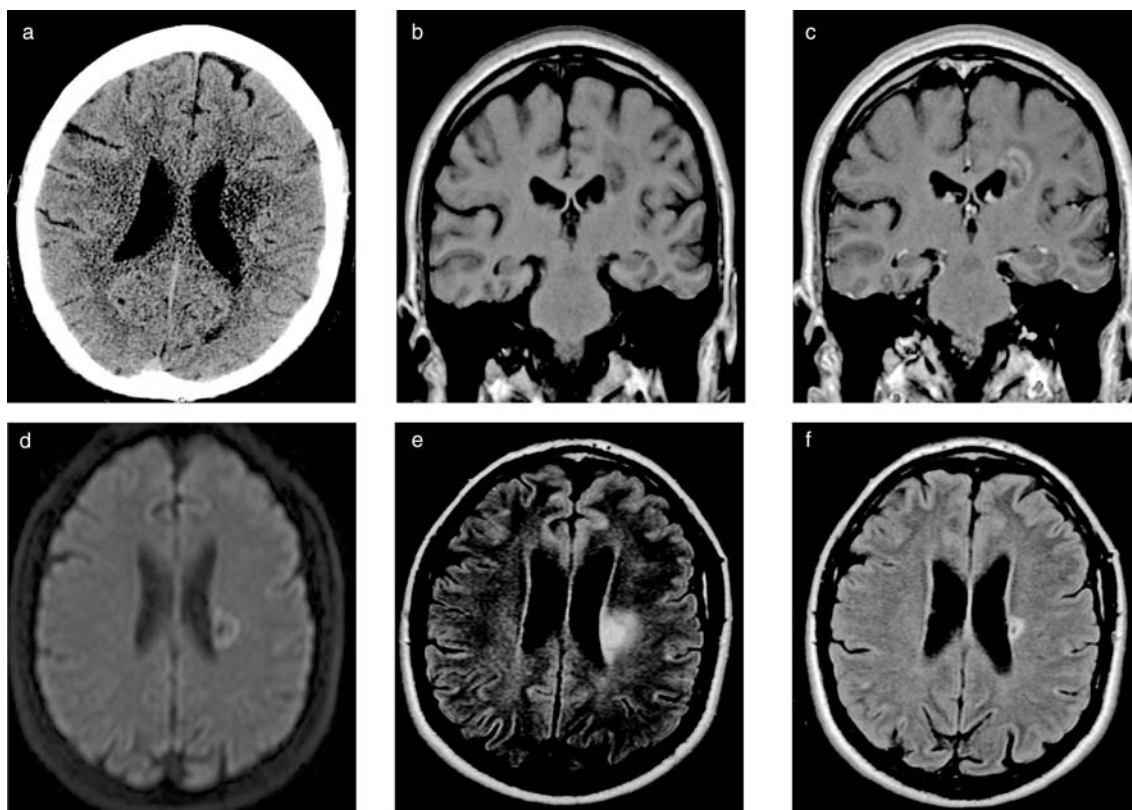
A 58-year-old male awoke with a right hemiparesis and dysphasia. a) Non-contrast computed tomography brain scan showing an area of hypodensity in the left corona radiata. b) T1-weighted magnetic resonance imaging (MRI) performed two weeks later showing hypointensity in the left periventricular region. c) Contrast-enhanced T1-weighted MRI showing peripheral enhancement in this lesion. d) Diffusion-weighted imaging showing restricted diffusion in the periventricular lesion suggestive of ischaemia or demyelination. e, f) Fluid attenuated inversion recovery images showing sequential attenuation of the periventricular lesion at zero and six months following treatment with intravenous methylprednisolone.
